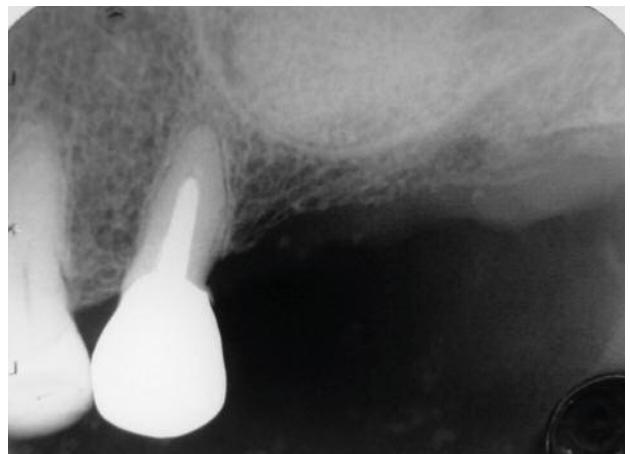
X-ray immediately post-op showing the placement of the β -Tricalcium Phosphate on the maxillary sinus floor -radiolucent area- (day 0).
